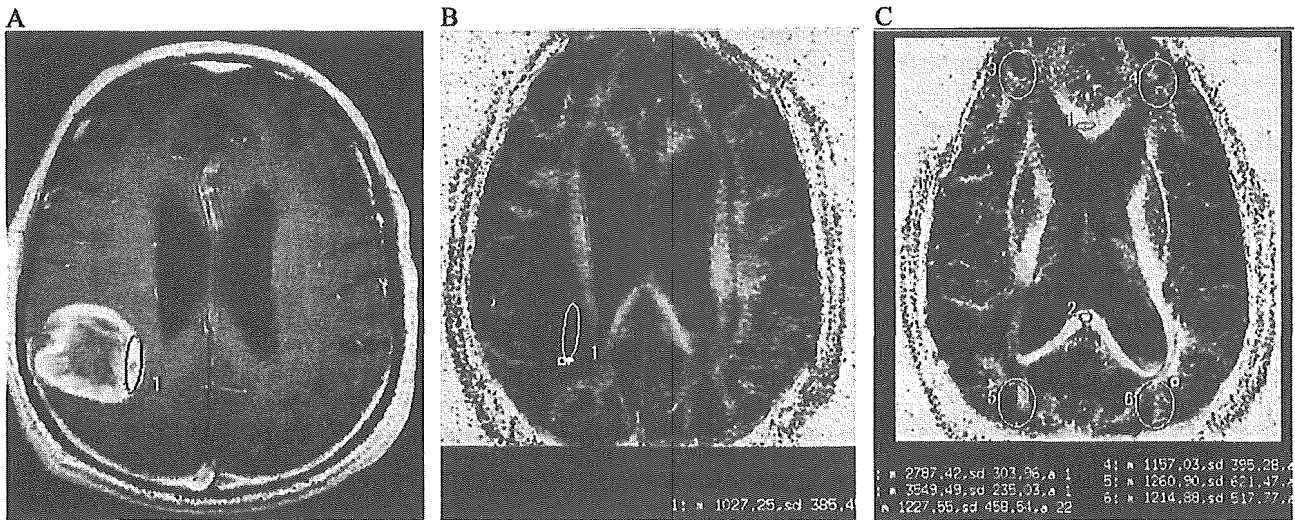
Locations of ROI in a patient with glioblastoma of the right parietal lobe. A, Gadolinium-enhanced T1-weighted MR image. Circle, ROI within a ring-enhancing lesion of the tumor. B, The coregistered FA maps from DTI. The ROI that was determined from the gadolinium-enhanced T1-weighted MR image was transferred onto a FA map. C, FA map for NWM. Because the tumor was situated in the parietal lobe, only FA values in ROIs of the contralateral frontal lobe (No 4) and the genu (No 1) were accepted.
